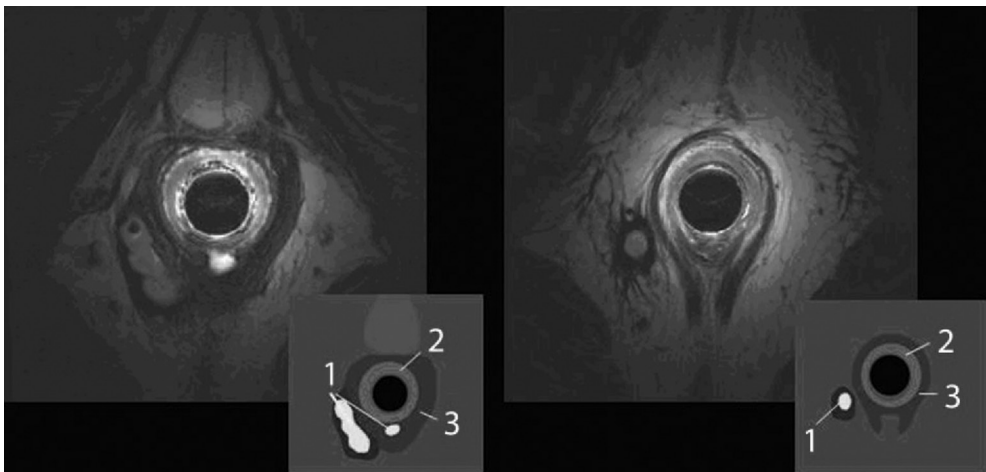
MR images of classic horseshoe fistula. 1=fistula; 2= internal anal sphincter; 3 = external anal sphincter.
